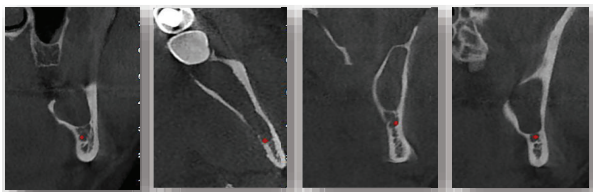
CBCT scan showed a cavity in the left mandibular ramus region (red point showed mandibular nerve)
